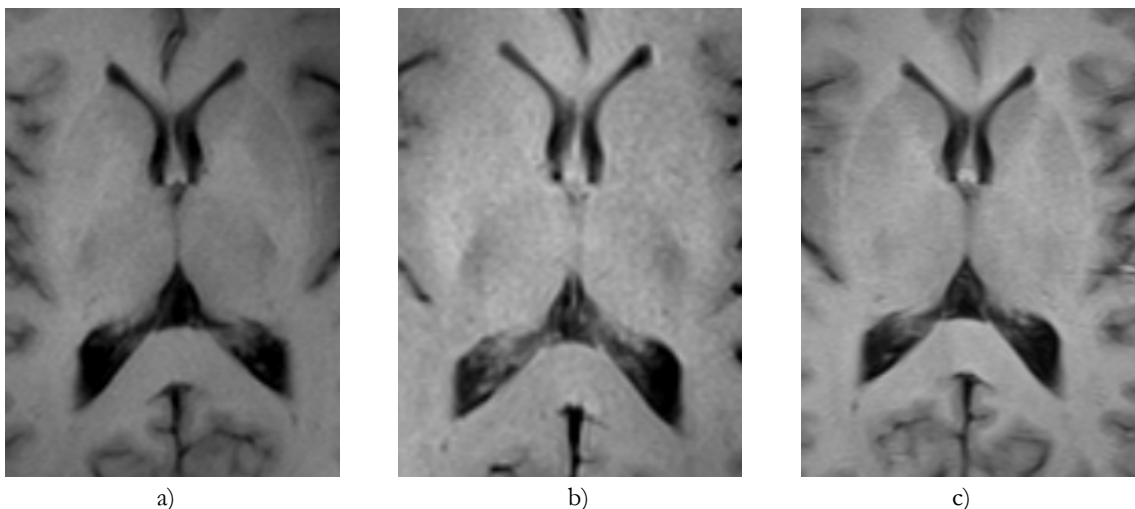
T1-weighted magnetic resonance images acquired at 3 Tesla. Gradient-echo (a) and fluid-attenuated inversion recovery (c) images display higher contrast between deep grey matter nuclei and the surrounding white matter than the spin-echo (b) image.
